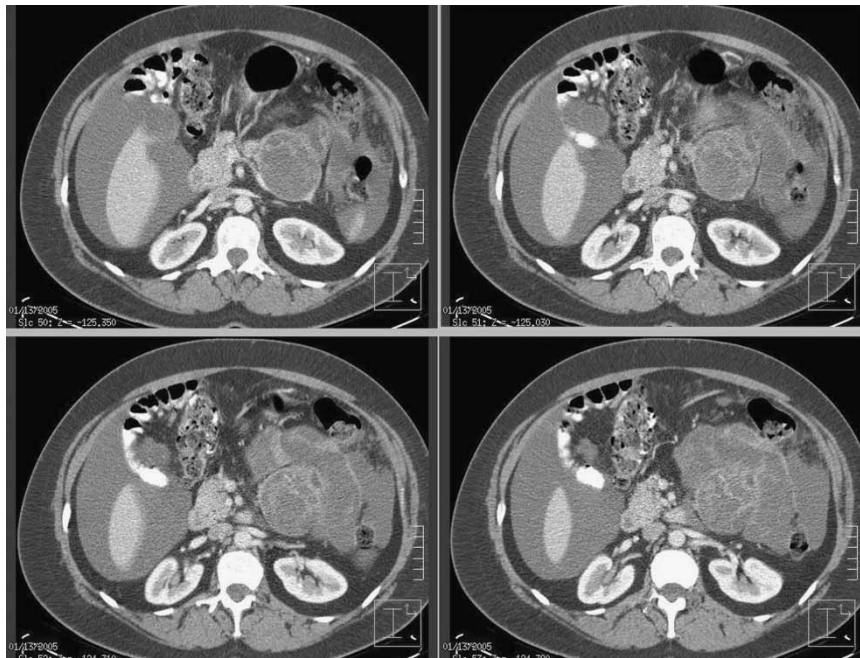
A CT scanning showed a large multiloculated process in the pancreatic body. The tumour was adherent to and compressed the splenic vein, and further grew in close proximity to the mesenteric root, the renal vein and the transverse colon. The tumour was free from the superior mesenteric vessels, and no metastasis to lymph glands, liver or other distant organs could be detected.
